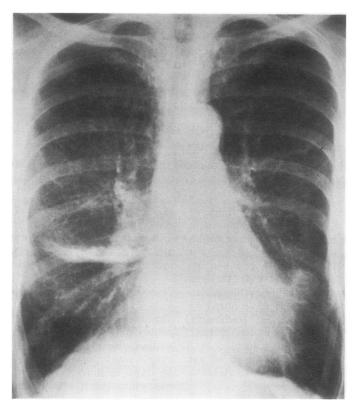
Postero-anterior chest radiograph taken approximately one month after the onset of breathlessness, 20 months after diagnosis of multiple myelomatosis, showing a lamellar shadow in the right lung and a rounded shadow in the left lung.
